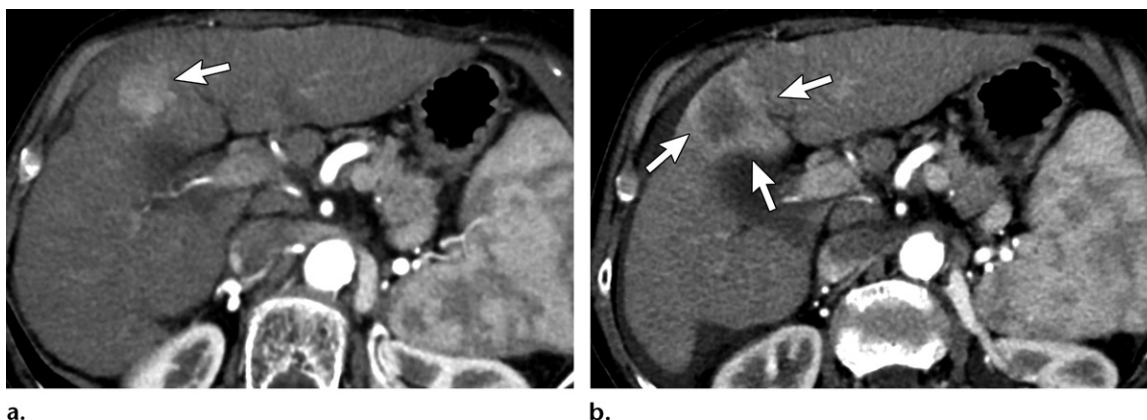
Peritumoral edema and inflammation in a 78-year-old woman with liver cirrhosis. (a) Axial pretreatment arterial phase CT image shows HCC (arrow) in liver segment IV. (b) Axial arterial phase CT image obtained 3 months after treatment shows an apparent increase in size, with perilesional enhancement due to parenchymal inflammation (arrows).
